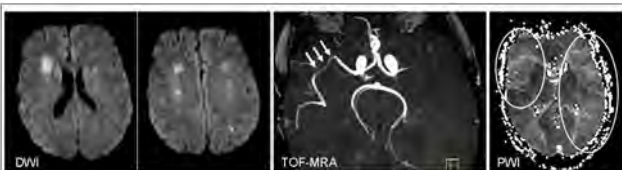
DWI images (left) show disseminated acute ischemic lesions in both MCA territories. On MRA (middle), there is a marked flow reduction with a lack of flow in the left MCA stem and a moderate narrowing of the distal right MCA (white arrows). Correspondingly, there is a delay of bolus arrival in both MCA territories on perfusion MRI (right).
